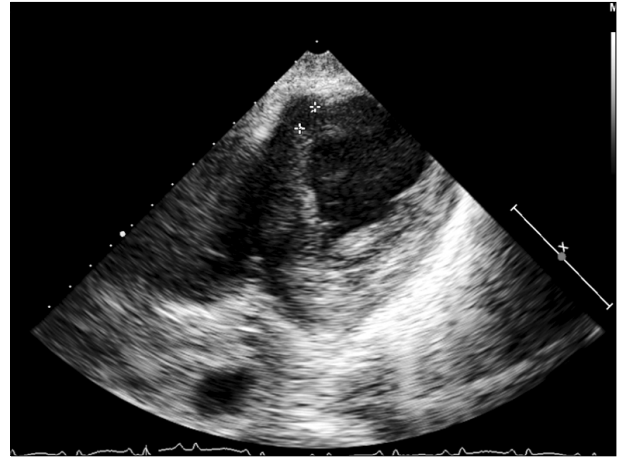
The postinfarct ventricular septal defect on the trans-thoracic echocardiography.
